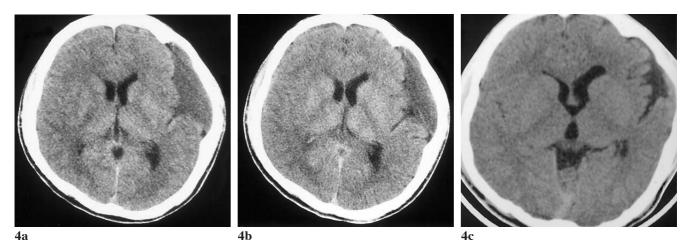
Follow- up CT of brain a. 1.5 months after discharged b. 3 months later c. and 1 year later. The hematoma was totally absorpted and the cyst became smaller. The pictures were indicated intracystic hemorrhage with rupture and adjacent subdural hematoma.
